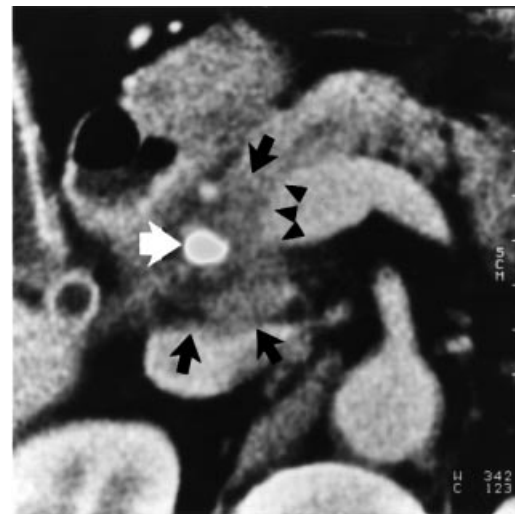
Pancreatic head carcinoma (black arrows). Computed tomography grade D vascular ingrowth with concave contour of the tumour towards the venous confluence (arrowheads). Stent in common bile duct (white arrow). At operation the lesion was irresectable owing to vascular ingrowth
